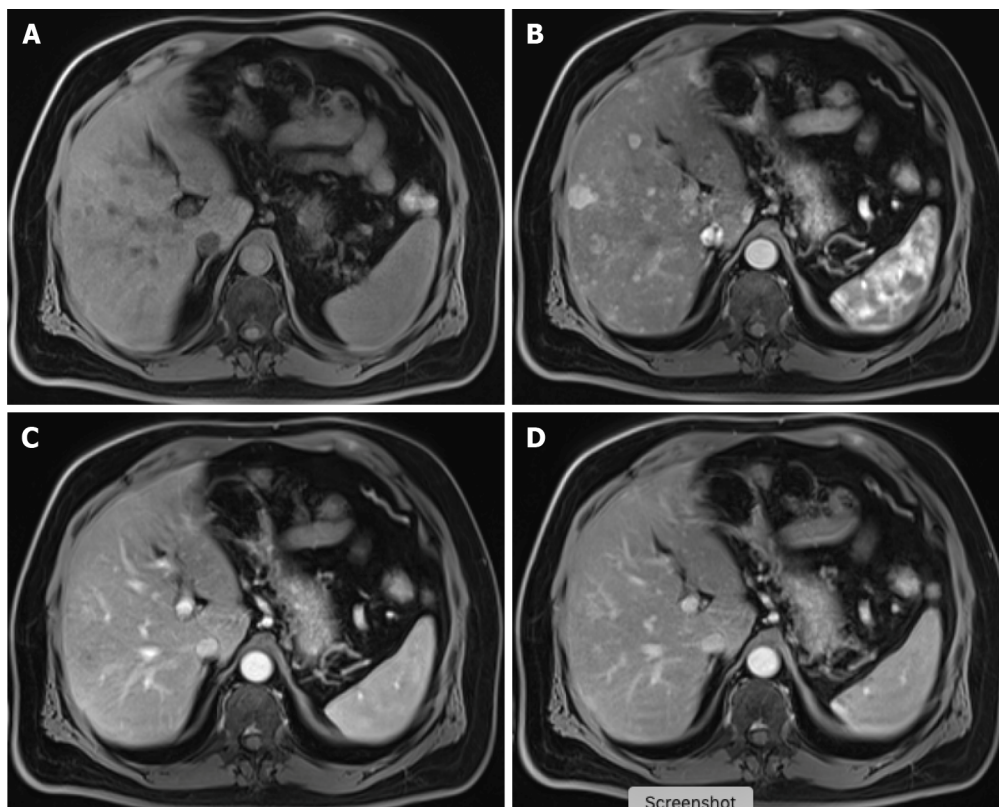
Carcinoid tumor with countless hypervascular liver metastases. A: Axial fat saturated (FS) non-contrast-enhanced magnetic resonance imaging (CE-MRI) T1-weighted imaging (WI) with barely imperceptible hypointense lesions; B: Axial FS CE-MRI T1-WI in the arterial phase detecting multiple hyperenhancing lesions compatible with hypervascular liver metastases; C: Axial FS CE-MRI T1-WI in the portal-venous phase shows fast fading of the lesions previously depicted; D: In the axial FS CE-MRI T1-WI in the delayed phase, the lesions become barely imperceptible. The arterial phase is crucial for the detection of hypervascular metastases.
